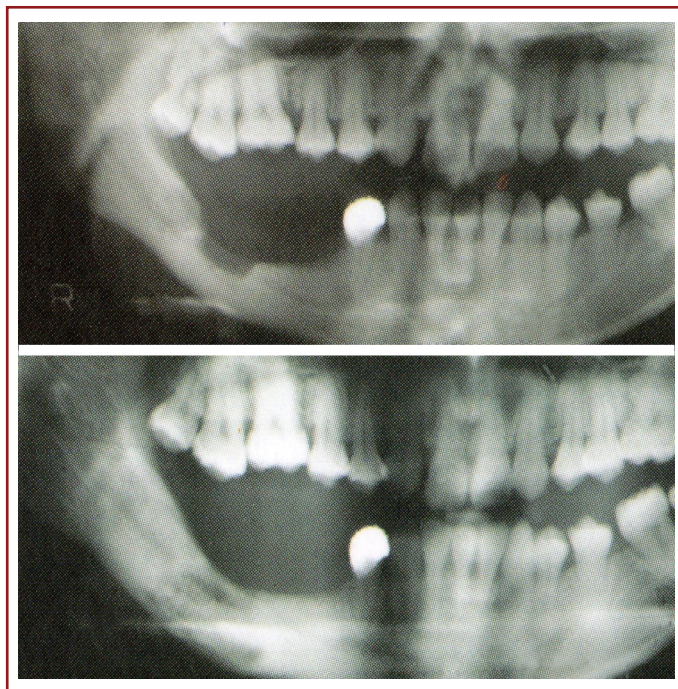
Upper: Bone defect due to chronic osteomyelitis in the right corpus region of the mandible, panoramic X-ray image. (Case 1) Lower: Panoramic mandible X-ray image taken after 40 sessions of hyperbaric oxygen therapy. It is observed that the bone defect in the right corpus is filled. (Case 1)
